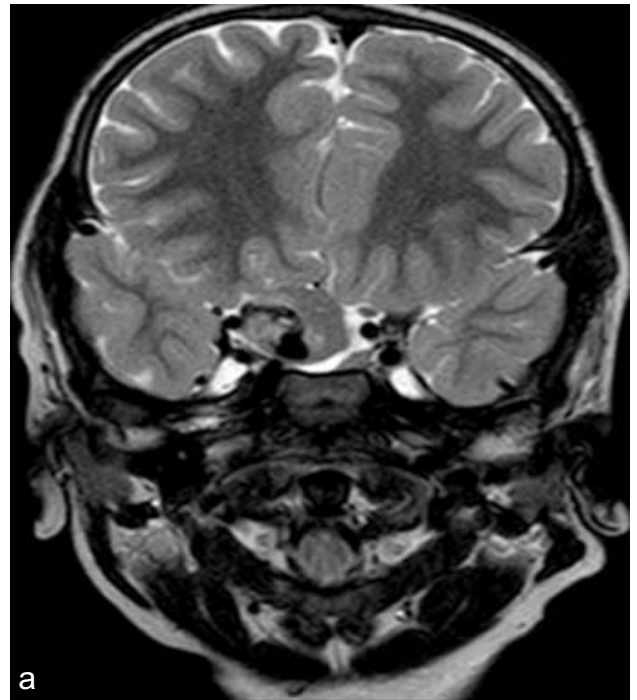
MRI Scan Brain Coronal and Sagittal views: The mass is seen to abut the optic chiasma and internal carotid arteries without evidence of invasion. Pituitary gland was separately visualized which appeared normal. Hence the diagnosis of sellar/suprasellar dermoid cyst was confirmed on MR imaging.
